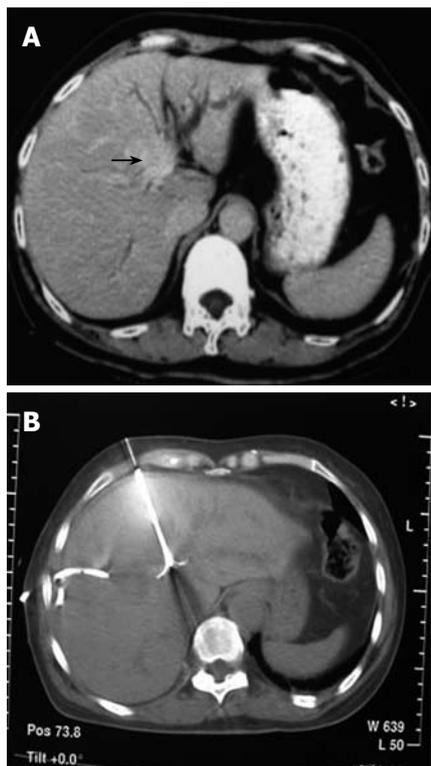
A case with type IIIb Klatskin tumor. A: Plain CT scan reveals that the tumor is in the main trunk of left hepatic duct with dilatation of branches; B: The patient underwent RFA under CT guidance after internal and external drainage for two weeks.
